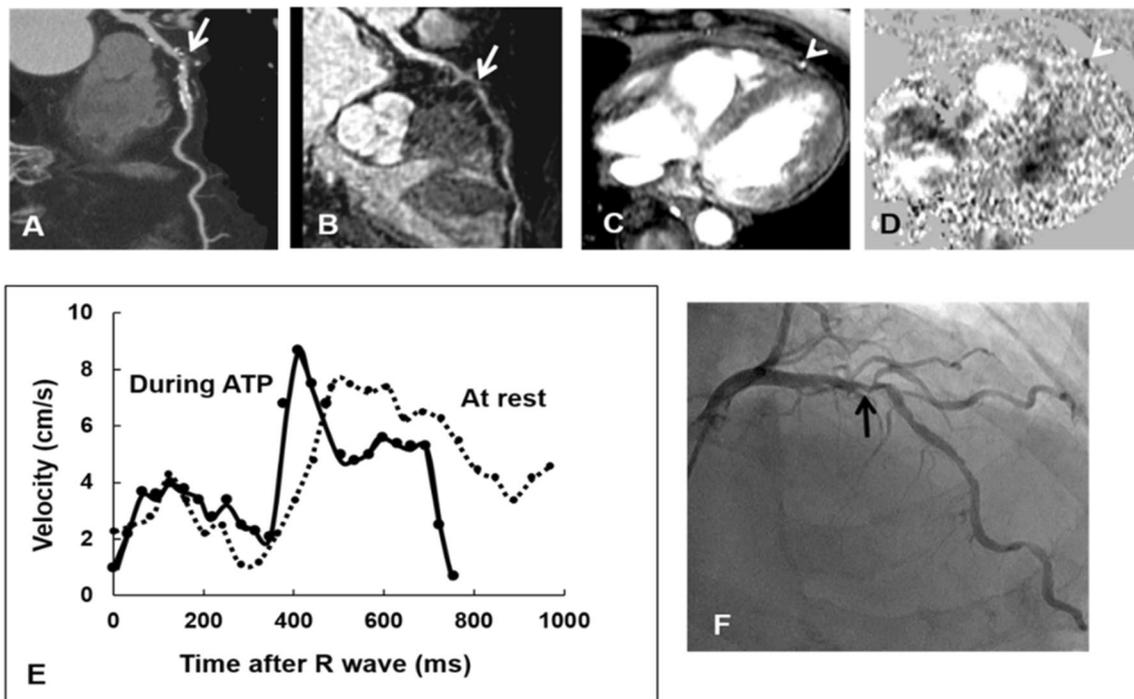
(vessel case 17) In a 77-year old man with Agastston score of 1549, moderate stenosis was suspected in the proximal LAD artery on CT angiography (a, arrow). MR angiography shows stenosis at the corresponding site of LAD artery (b, arrow). Magnitude image (c) and phase difference image (d) of the LAD artery distal to the stenosis are presented. e Time-velocity curves at rest and during
